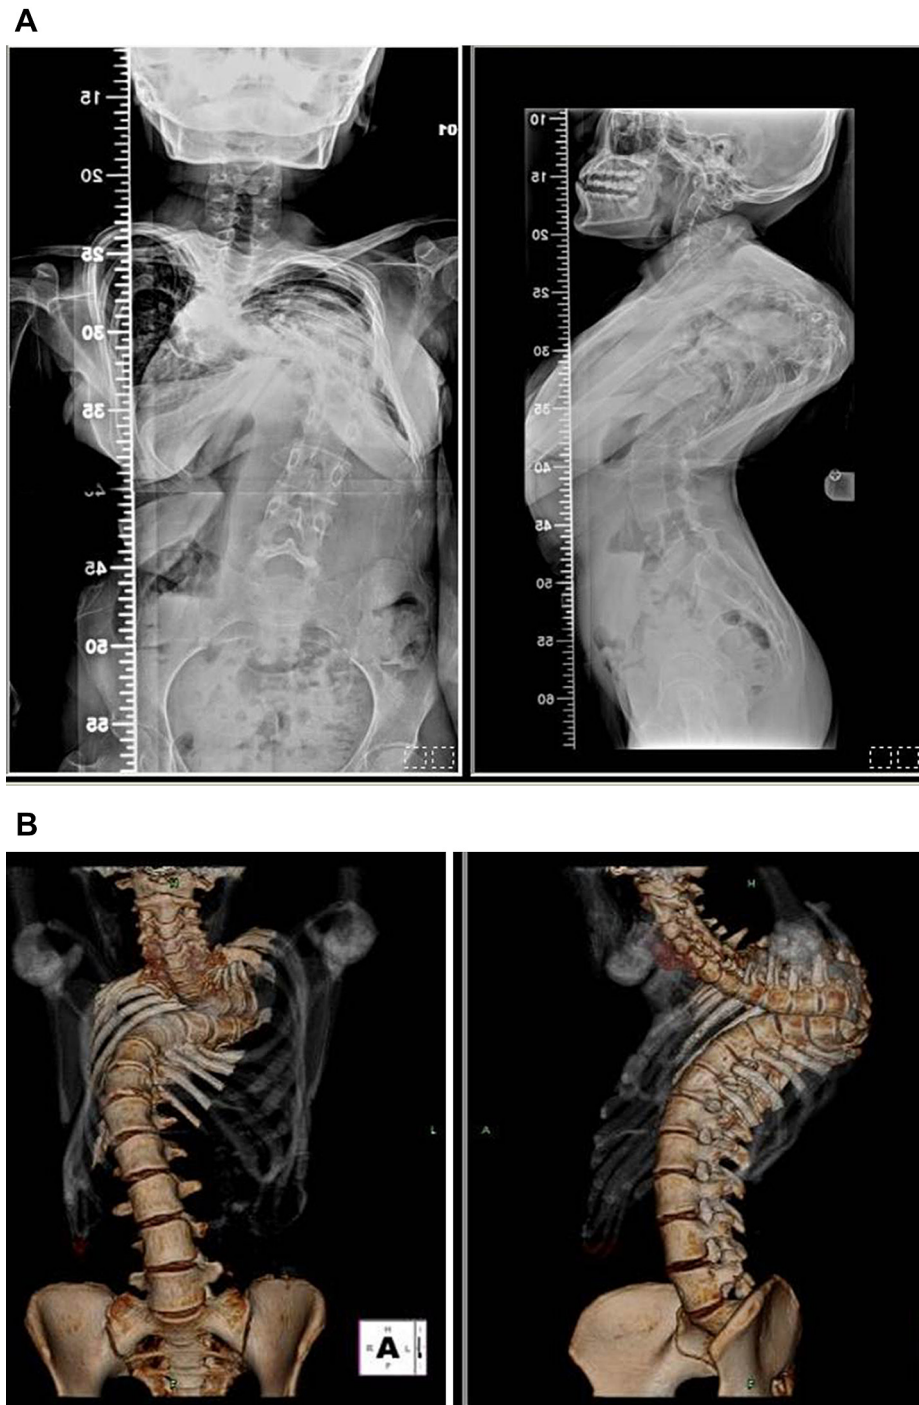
A 16-year-old girl with kyphoscoliosis and Cobb angle greater than 100° . (A) Radiograph, anterior–posterior and lateral view. (B) Spinal 3D computed tomography reconstruction.
